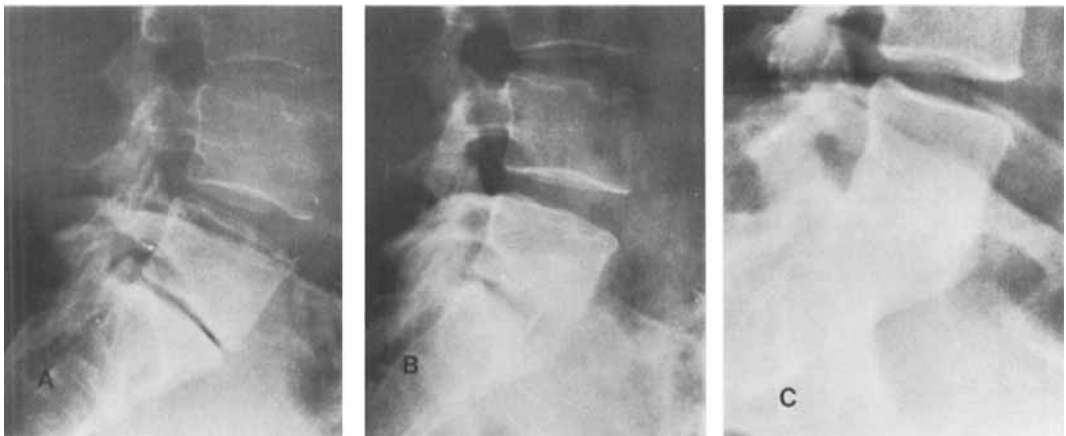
X-rays of a 43-year-old woman. A: Severe narrowing of the 5th lumbar disc and sclerosing of the end plates. B: Early postoperative X-ray. C: X-ray 2 years postoperatively showing solid union.
